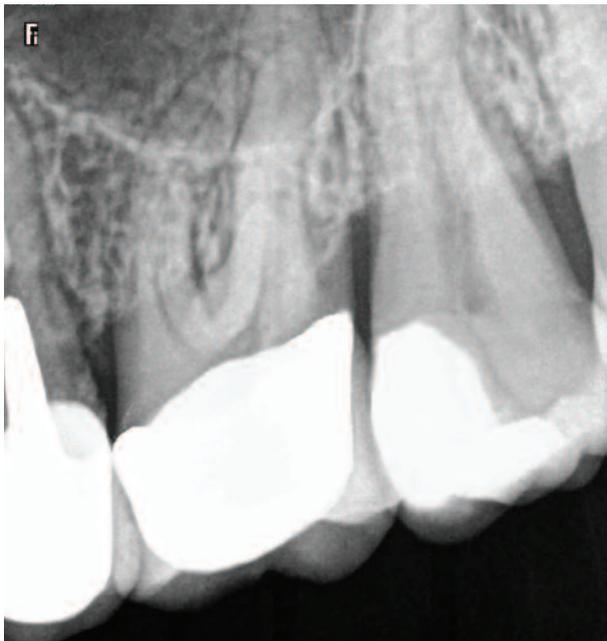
Radiograph six months post treatment. No signs of periapical pathology could be observed.
